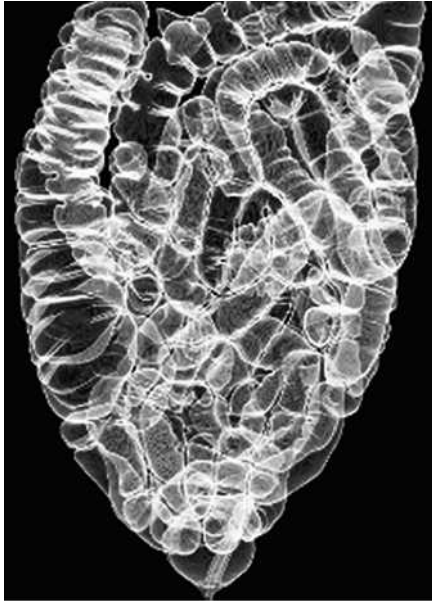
Spontaneous cyst resolution. Air-containing cysts are no longer apparent on computed tomography colonography 3D reconstruction images, taken 17 months after initial cyst detection.
